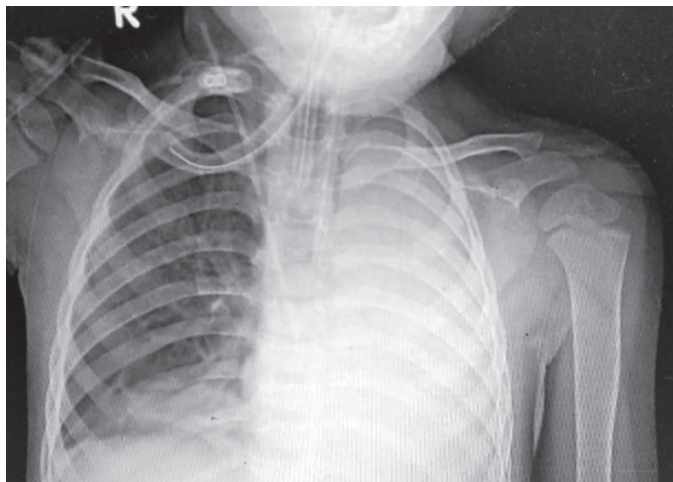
Left lung collapse on chest radiograph
